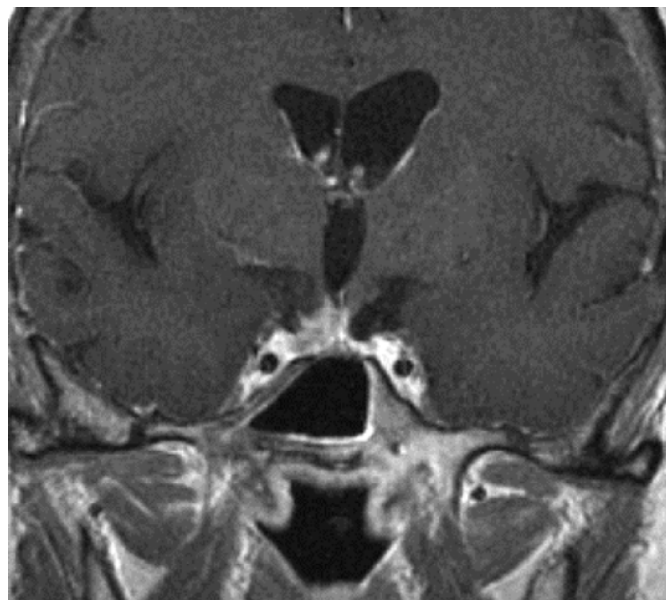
Coronal contrast-enhanced T<sub>1</sub>-weighted MR image of the patient shown in Fig. 1 taken 24 months after stereotactic radiotherapy.
